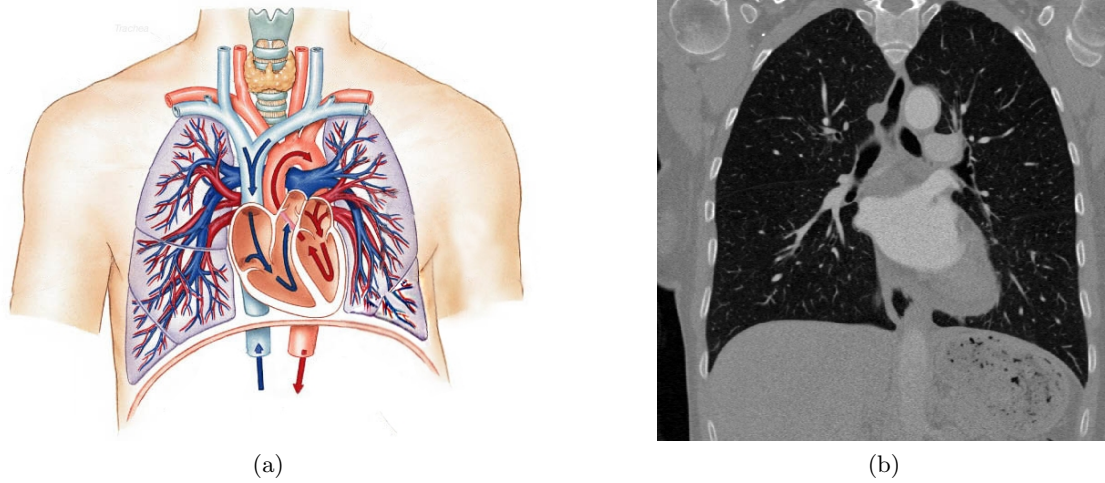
(a) Pulmonary circulation: deoxygenated blood leaves through the right ventricle, through the pulmonary artery to the capillaries where the gas exchange takes place. Blood leaves the capillaries through the pulmonary vein to the heart, where it re-enters at the left atrium (© James W. Clack, www.iupucbio2.iupui.edu/anatomy). (b) Coronal view of the thorax from a CT-image.
